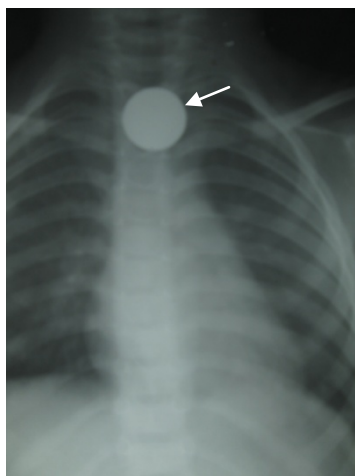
Chest radiographs. Frontal view. Coin in upper thoracic part of esophagus (arrow) at the child aged 2,5 years. Foreign body
